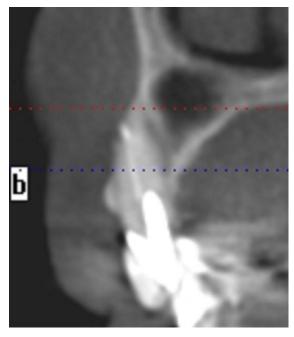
An axial view taken in the premaxillary area can sometimes show anterior sinus deflections subnasally that present on the CT scan as round central alveolar defects. (The so-called bullet sign is well shown in this dentate patient not included in the study.)
